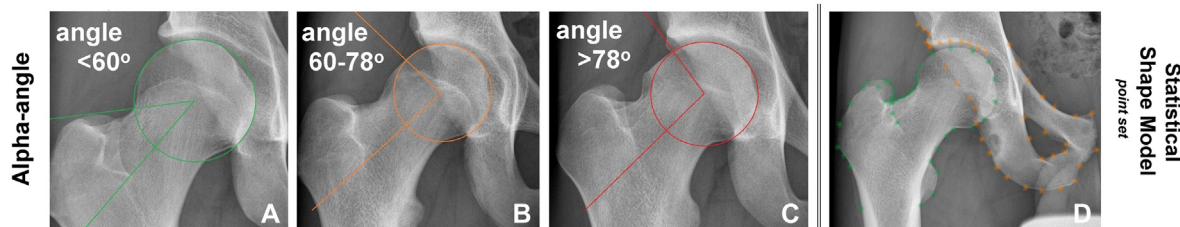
The alpha angle as measured on AP radiographs (A–C). The best fitting circle is drawn around the femoral head and then a line from the centre of the head through the centre of the neck. From the centre of the head, a second line is drawn to the point where the superior surface of the head–neck junction first departs from the circle. The angle between these two lines is the alpha angle, resulting in values $<60^\circ$ in hips with a spherical femoral head (A); a cam deformity is defined by an alpha angle $>60^\circ$ (B); and a pathological cam deformity by an alpha angle $>78^\circ$ (C). The point set of a shape model is shown in (D), where the shape of the hip is defined by a set of points which are always positioned on the same anatomical landmark.
